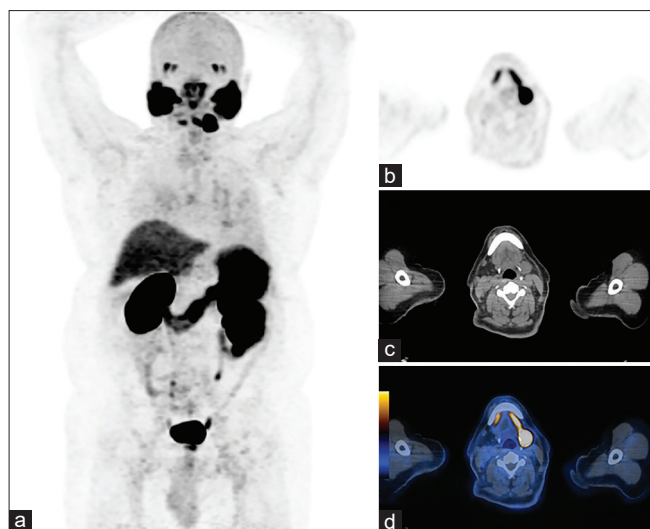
Anterior maximum intensity projection image (a) of ^{68}Ga -prostate-specific membrane antigen positron emission tomography-computed tomography shows absent submandibular salivary gland on the right side as well as prominence of the contralateral one. The absent gland is better depicted on ^{68}Ga -prostate-specific membrane antigen positron emission tomography (b), computed tomography (c), and fused positron emission tomography-computed tomography image (d)
